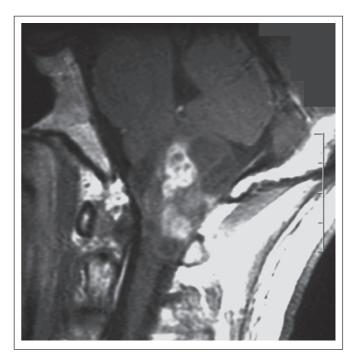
Brain MRI (T1-weighted/gadolinium) showing a contrast-enhanced lesion in the medulla oblongata. The tumour has dorsal exophytic and cystic components.
